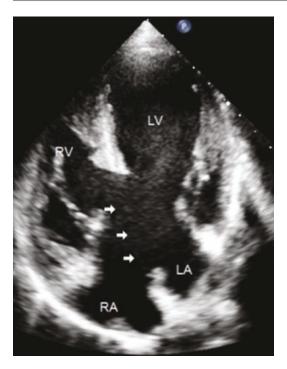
TTE 2D apical 4 Chamber view. Arrows point the AVSD (ASD and VSD) with a common atrioventricular valve. *S* superior bridging leaflet, *I* inferior bridging leaflet, *M* mural leaflet
